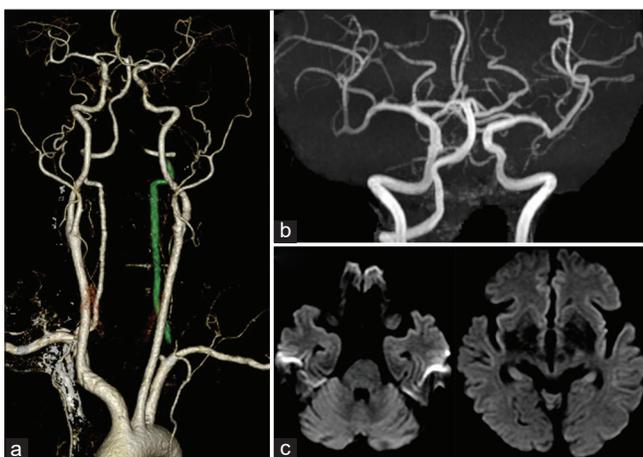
Postoperative images. (a) Postoperative computed tomography angiography showed complete occlusion of the left vertebral artery. The green line indicates the coil mass. (b) Postoperative magnetic resonance angiography showed occlusion of the left vertebral artery. (c) Postoperative diffusion-weighted image showed no ischemic lesion.
